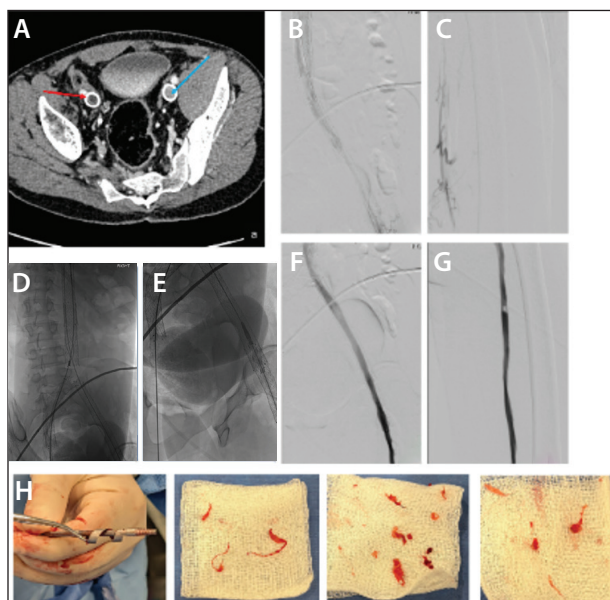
CT venography showing an occluded right EIV stent and patent left EIV stent (A). Little flow through stent with reflux into distal collaterals (B). Significant chronic obstruction in femoropopliteal vein (C). Recana collection basket deployed in IVC stent (D). Recana debulking catheter (E). Post-Recana robust flow with greater luminal area (F). Post-Recana native vein flow restored (G). Material captured and removed (H).
